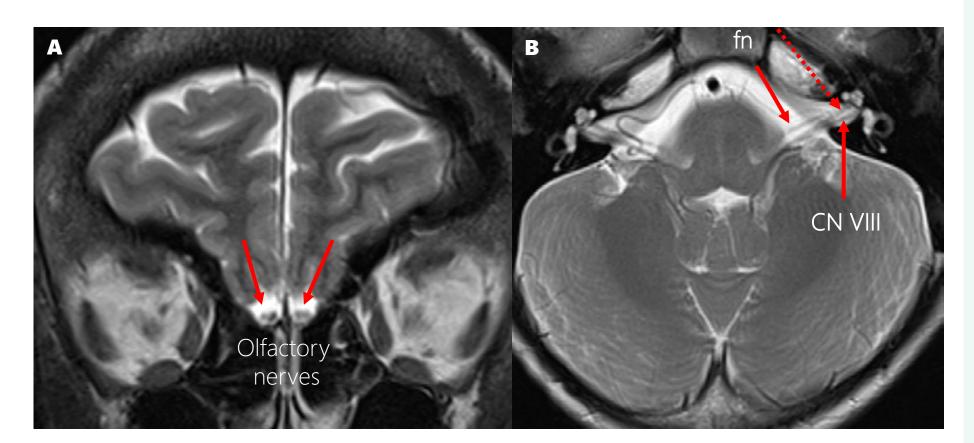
Anatomy of the cranial nerves. (A) olfactory bulbs as seen on a coronal T2-weighted MR image (arrows). B. Cochleovestibular nerves (CN VIII) as seen on an axial T2-weighted MR image (arrows). The cochlear nerve (dashed arrow) lies anterior to the vestibular nerves (solid arrow).
